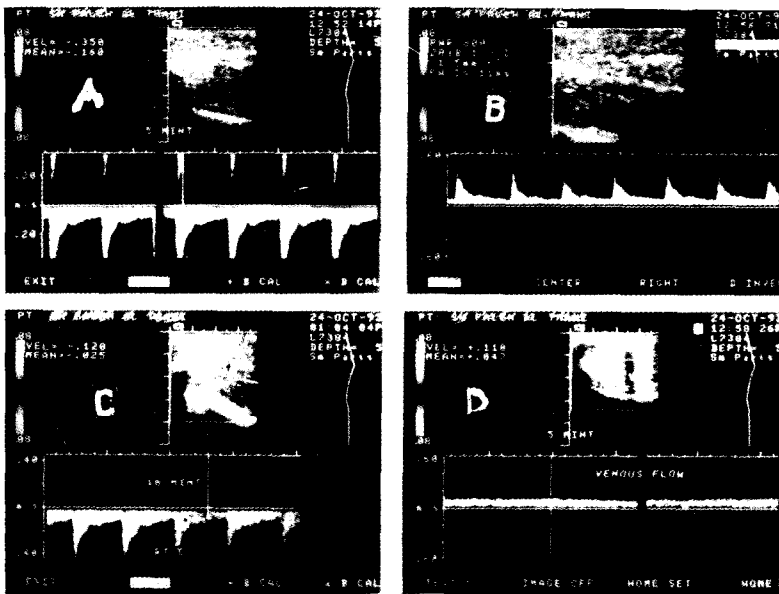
Colour doppler findings in a case of venogenic impotence. A&B) Normal arterial in flow. C) Persistent and diastolic flow of 12 cm/sec. D) Persistent flow in the dorsal vein.
